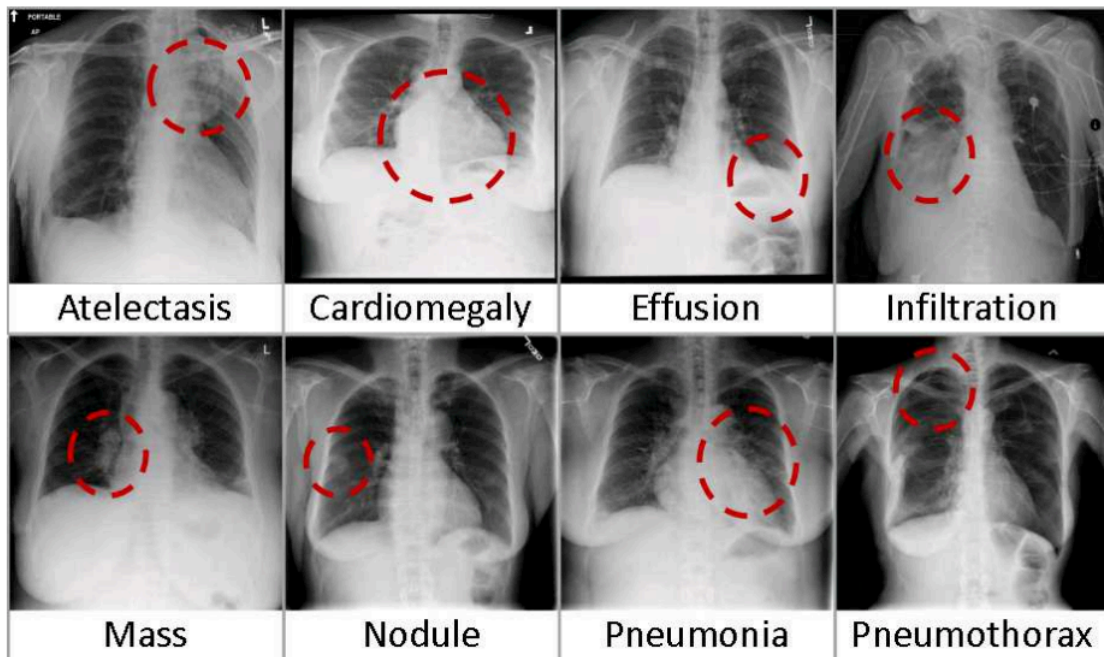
Several chest radiography automatically labeled with associated diseases extracted from Wang *et al.* work.³³ For example, air trapping (atelectasis) results in a high residual lung volume and a flattened diaphragm.
